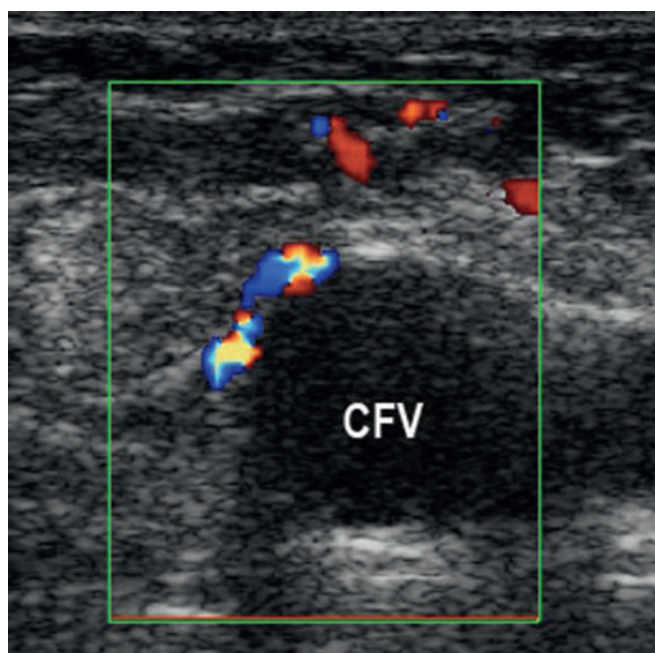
Duplex ultrasound. Neovascularization at the previous area of the saphenofemoral junction after high ligation. CFV, Common femoral vein. (Courtesy Dr Gillet.)
